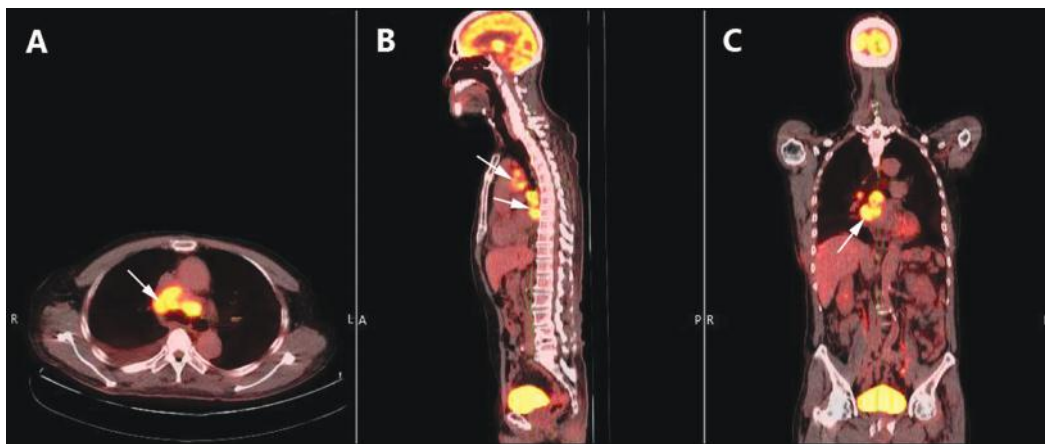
Whole body FDG-PET-CT scan images demonstrating multiple intensely hypermetabolic lymphadenopathies in the (A) paratracheal (arrow), (B) pretracheal and prevertebral (arrows), and (C) subcarinal (arrow) regions.
